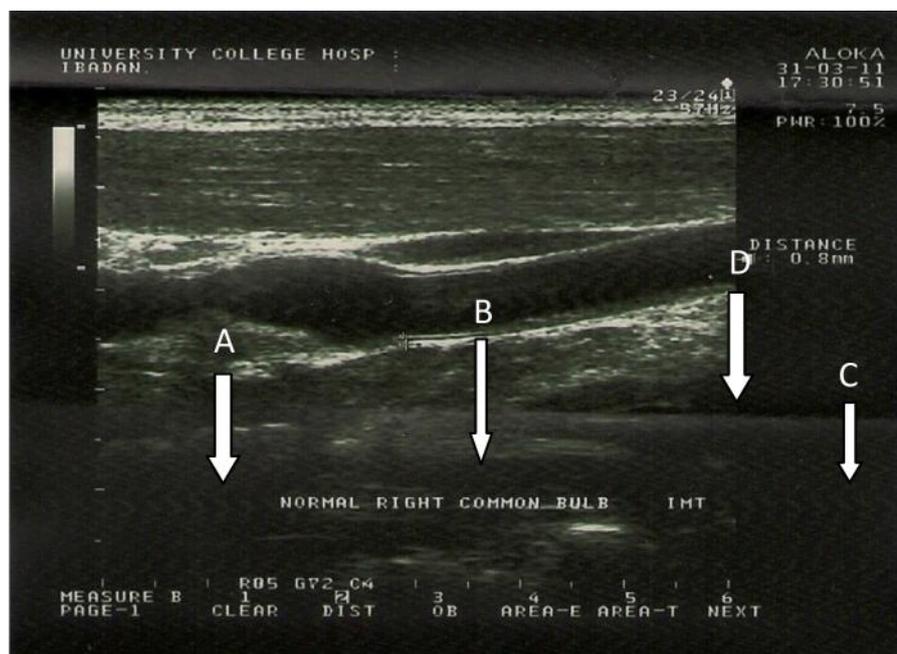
Longitudinal Scan, B-Mode Ultrasound Image showing how the IMT is measured (Cursors). A: Internal Carotid Artery; B: Carotid Bifurcation; C: Common Carotid Artery; D: Internal Jugular Vein.
